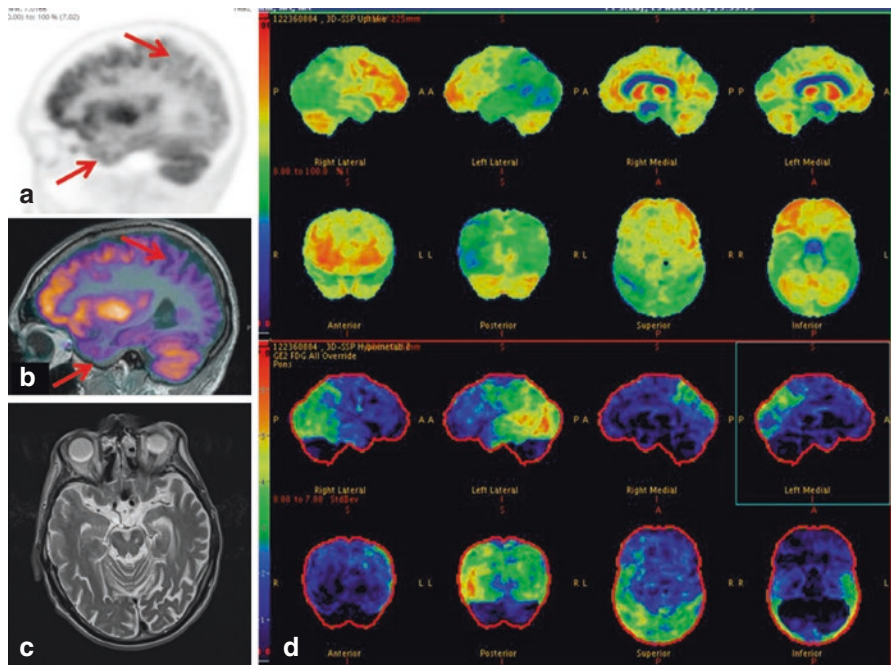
(a–d) Sagittal ^{18}F FDG PET (a), sagittal fused ^{18}F FDG PET/MR (b), axial T2WI (c) and Z-score maps (d) show reduced FDG uptake in the temporoparietal lobes bilaterally (a, b arrows) corresponding to cerebral atrophy on MRI (c) and confirmed on quantification assessment (d), in keeping with Alzheimer’s dementia.
